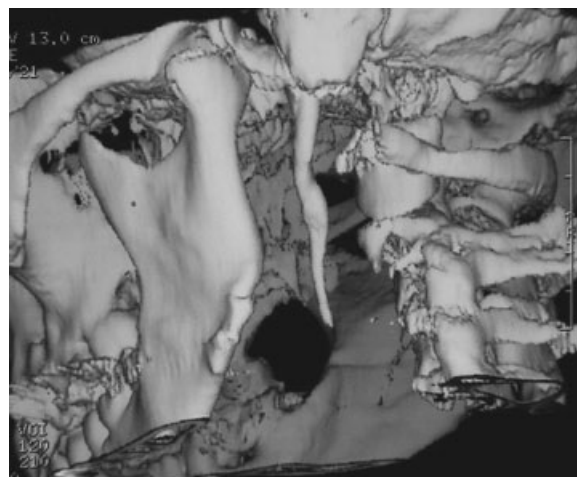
Three-dimensional computed tomography of styloid process.
